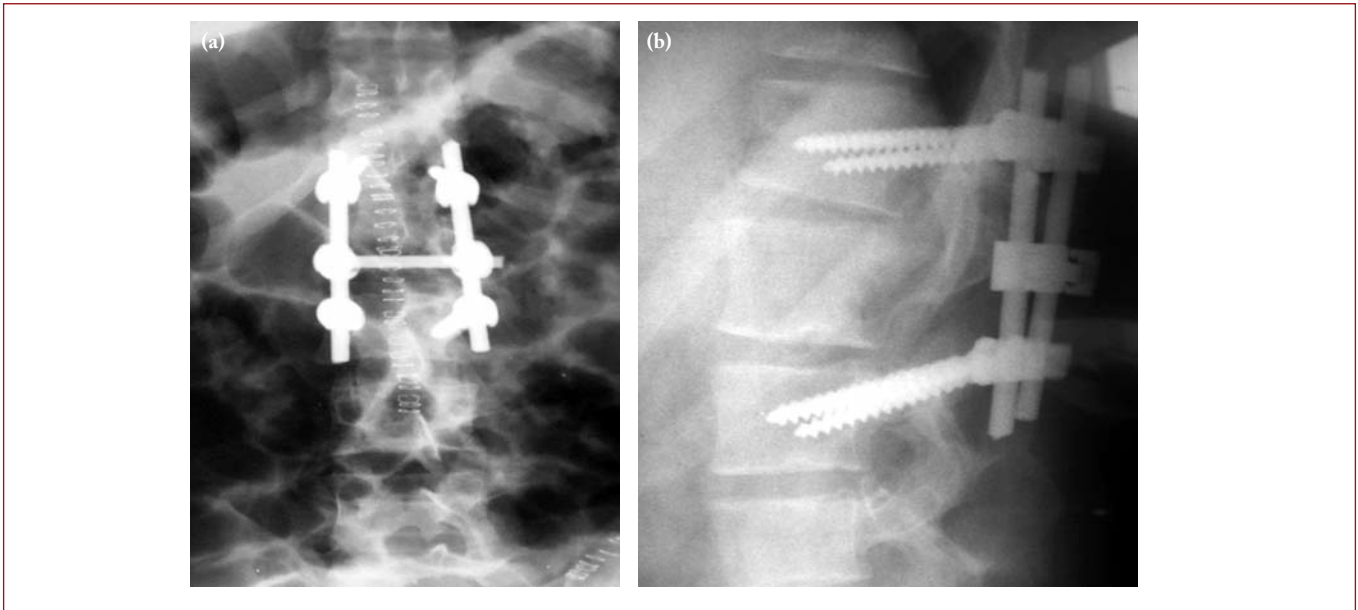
a. Postoperative AP X-ray, b. postoperative lateral X-ray.
